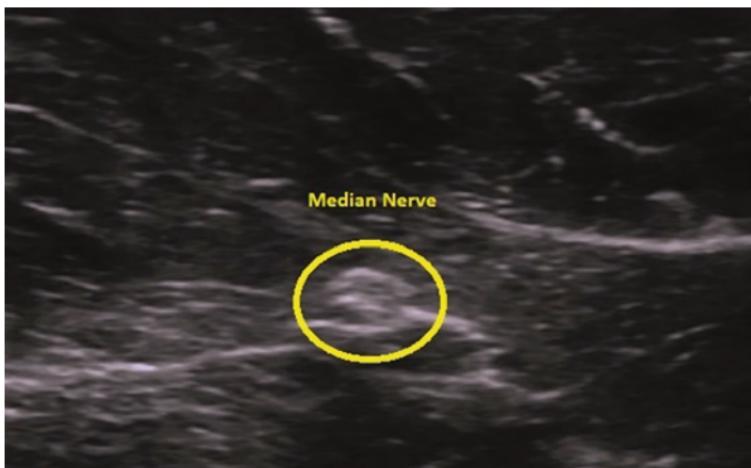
Ultrasound image of median nerve at the forearm
